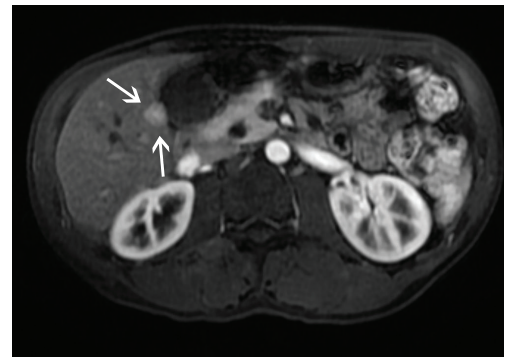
Small hepatocellular carcinoma detected on contrast enhanced MRI not seen on ultrasound or CT.
